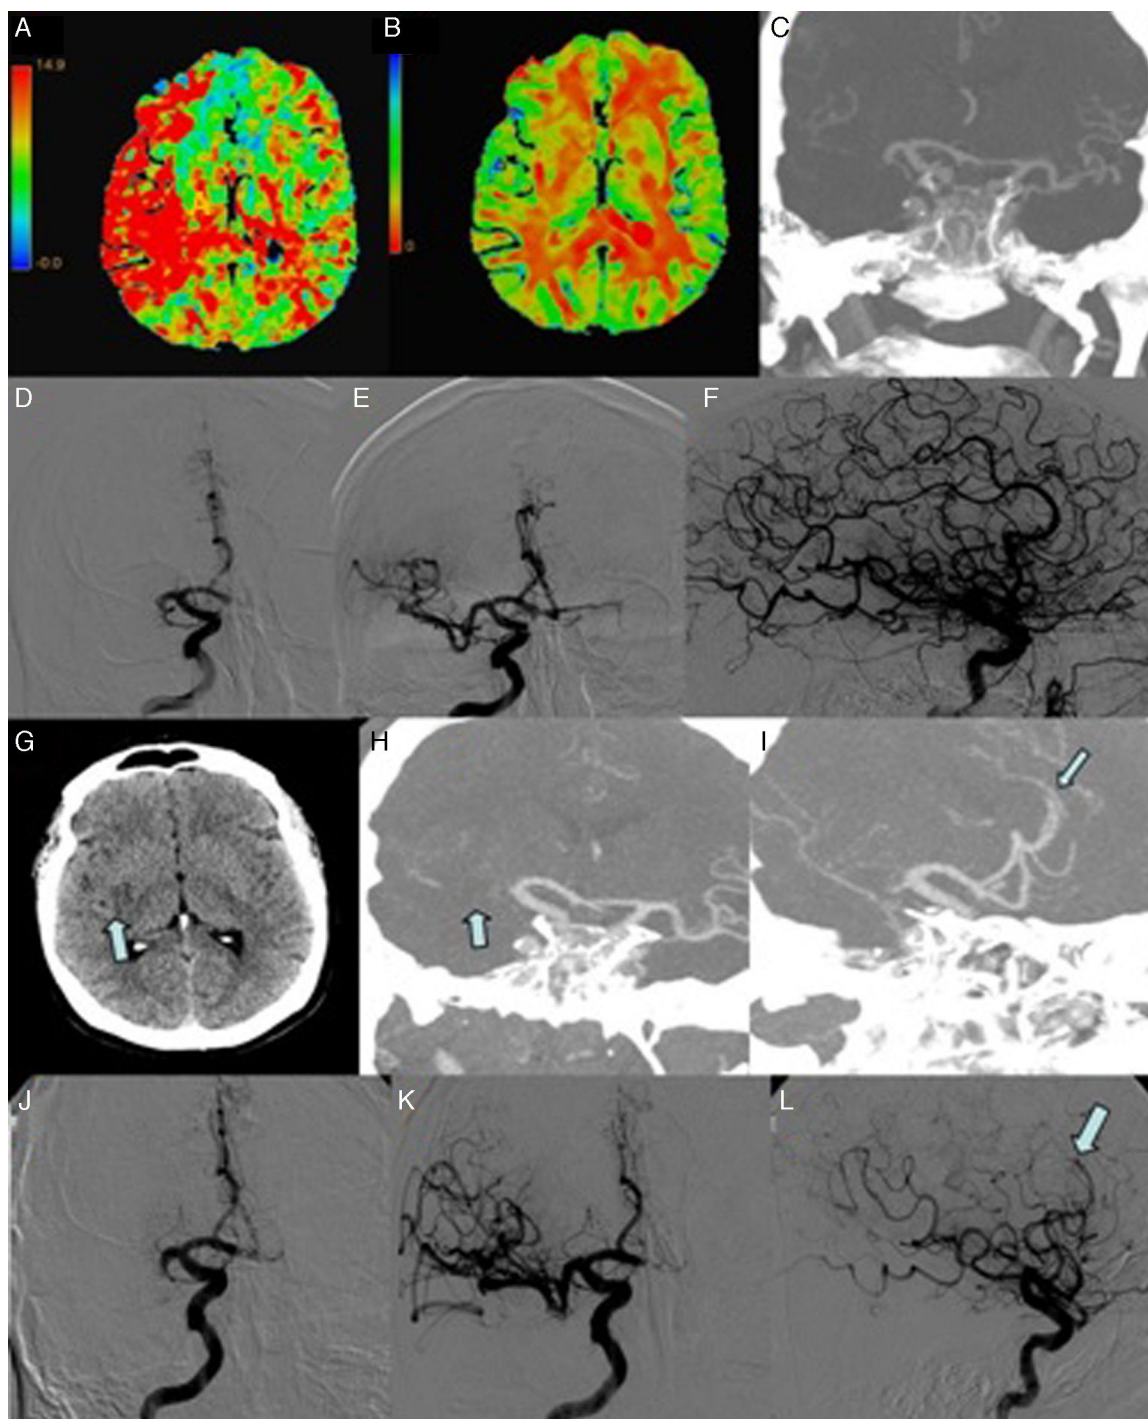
First ischemic stroke (A-F). (A) Multiparametric CT scan: map of mean transit time showing delayed blood flow in the territory of the right MCA. (B) Multiparametric CT scan: map of cerebral blood volume revealing low volume in the right lenticular nucleus. (C) CT-angiography: occlusion of the M1 segment of the right MCA. (D) Angiography: occlusion of the M1 segment of the right MCA. (E and F) Complete recanalisation (TICI grade 3) was achieved with 2 passes. 28 hours after the first event (G-L). (G) Brain CT scan showing a small infarction in the right insula and lenticular nucleus (arrow). (H) CT-angiography: occlusion of the M1 segment of the right MCA (arrow). (I) CT-angiography: occlusion of the A3 segment of the right ACA (arrow). (J) Angiography (AP projection): occlusion of the M1 segment of the right MCA. (K and L) Recanalisation of the MCA (TICI grade 2B) and persistent occlusion of the A3 segment of the right ACA (arrow).
